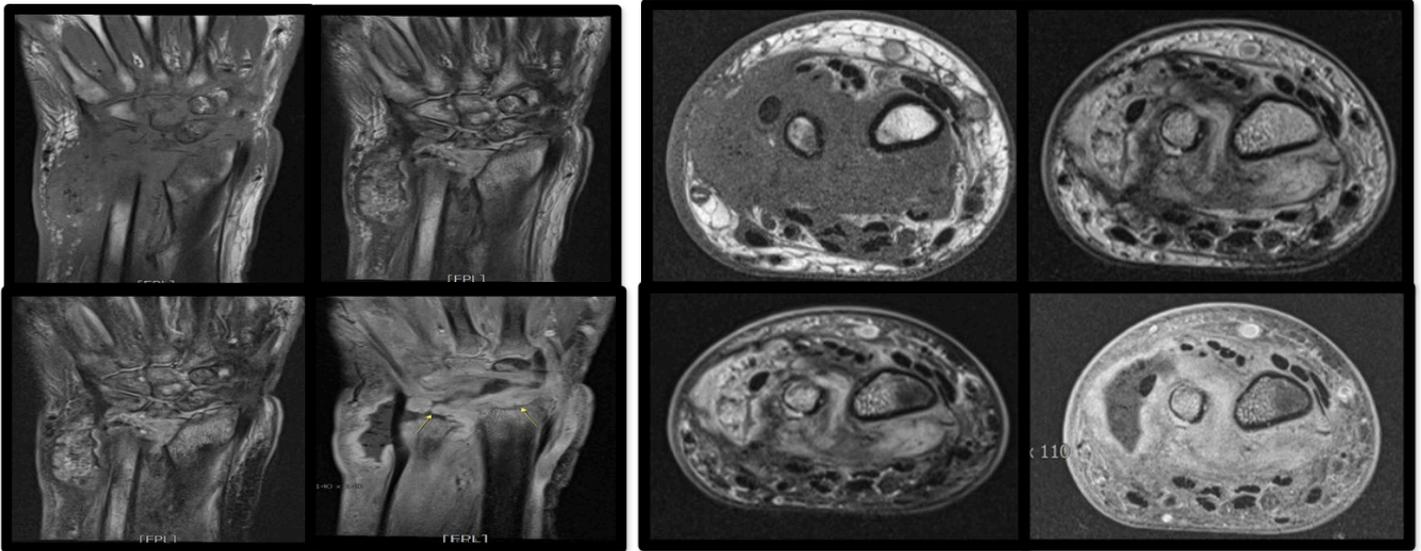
MRI film of left wrist at 2 months follow up, suggestive of erosive arthritis with gas forming abscess along ulnar side
